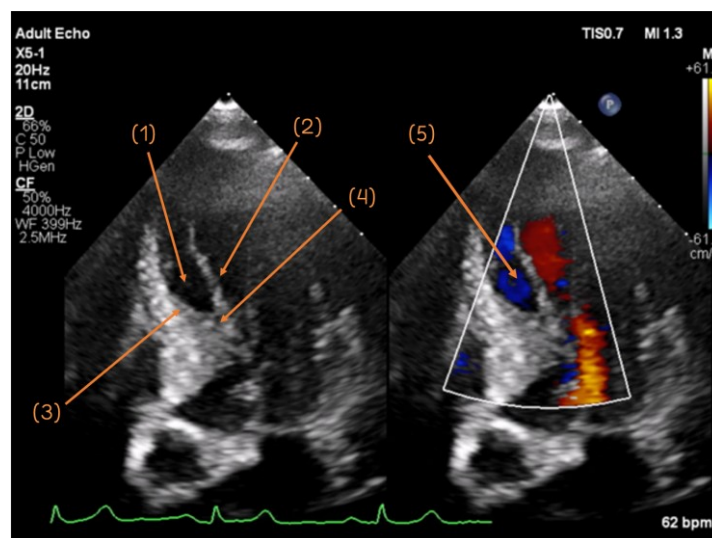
Signs of intramyocardial dissection from our patient, detected in transthoracic echocardiography. (1) Formation of neocavity with the echo-lucent center, (2) endomyocardial mobile inner border (3) outer side of neocavity lined by myocardium (4) continuity between the dissected myocardium and the ventricular cavity and (5) Doppler examination shows flow in the dissected myocardium
